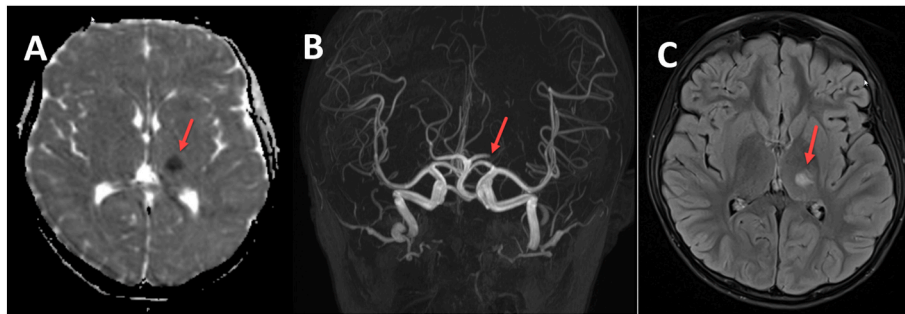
Acute Stroke in 9-year-old boy due to left P2 occlusion. A) acute diffusion imaging with ADC 8 h after symptom onset showing diffusion restriction in left posterior internal capsule and left posterior thalamus, B) TOF angiogram 8 h after symptom onset showing left P2 occlusion, C) FLAIR demarcation 30 h after symptom onset.
